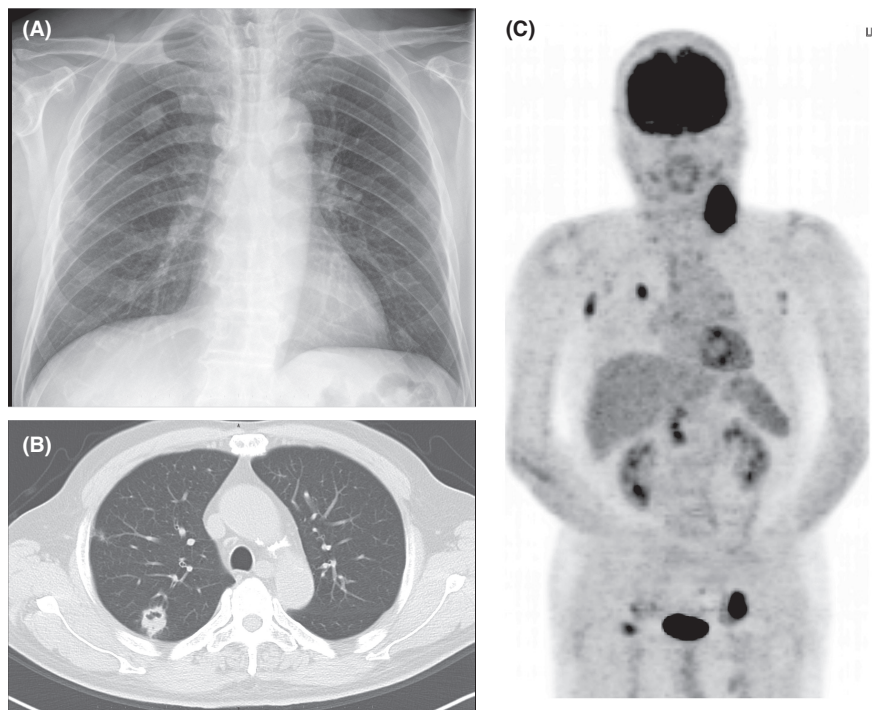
Findings of Chest radiography, CT of the chest and FDG-PET. (A) Chest radiography: A nodular shadow approximately 2 cm in maximum diameter was found in the upper right lung field. (B) CT of the chest: A 24 × 21 × 18 mm nodule with a cavity was found in the first segment of the upper right lobe. (C) FDG-PET: SUV max accumulation of 9.4 was observed in the nodule in the right upper lobe. In addition to strong accumulation in the left cervical lymph nodes, accumulation also occurred in both axillary lesions, near the pancreatic head, in both external iliac arteries, and in the right inguinal lymph nodes
